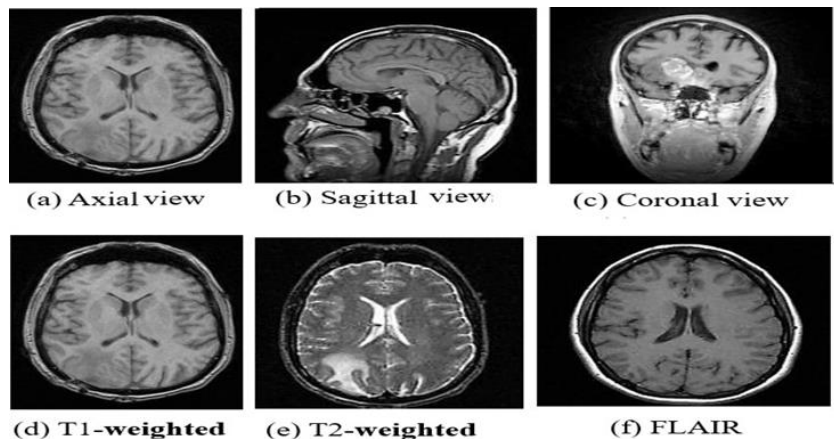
Sequences and plans of MRI tumor image [1].
